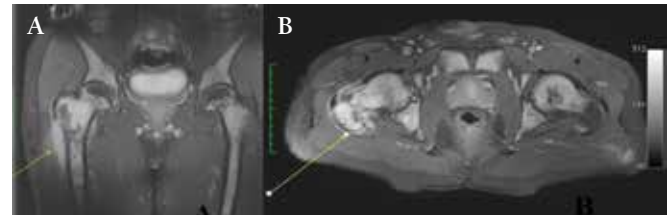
A) Metaphysodiaphyseal paracortical heterogeneous enhancement of the proximal femur in the post-contrast T1-weighted coronal image. B) Paracortical minimal signal increase is seen in the proximal femoral metaphysodiaphyseal part in coronal T2-weighted fat-suppressed image.
